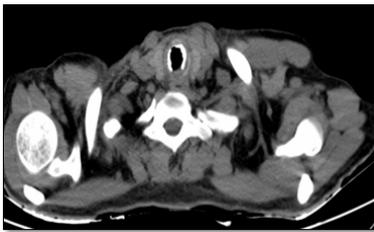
Axial image of plain CT Neck showing anterior wall calcifications and irregularity and nodularity sparing posterior wall.
